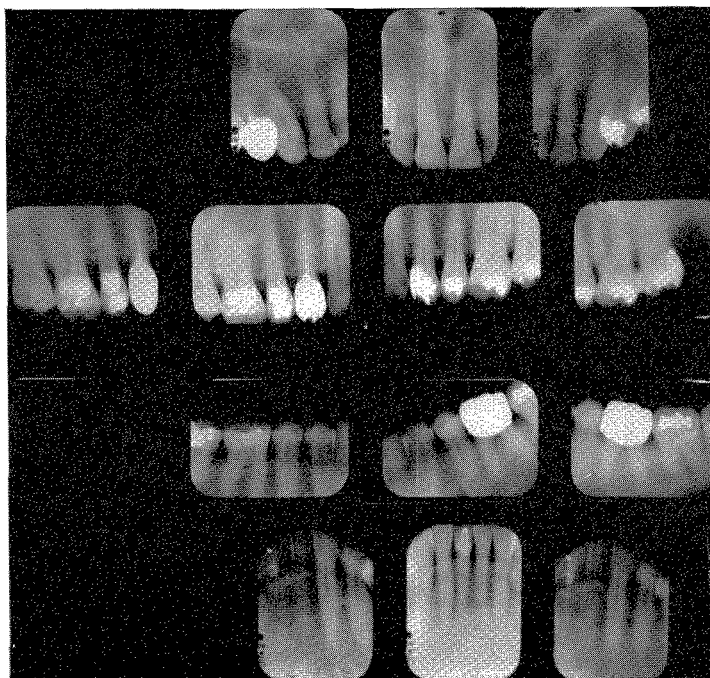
Roentgenograms taken in November, 1961, of the teeth shown in Fig. 616.
